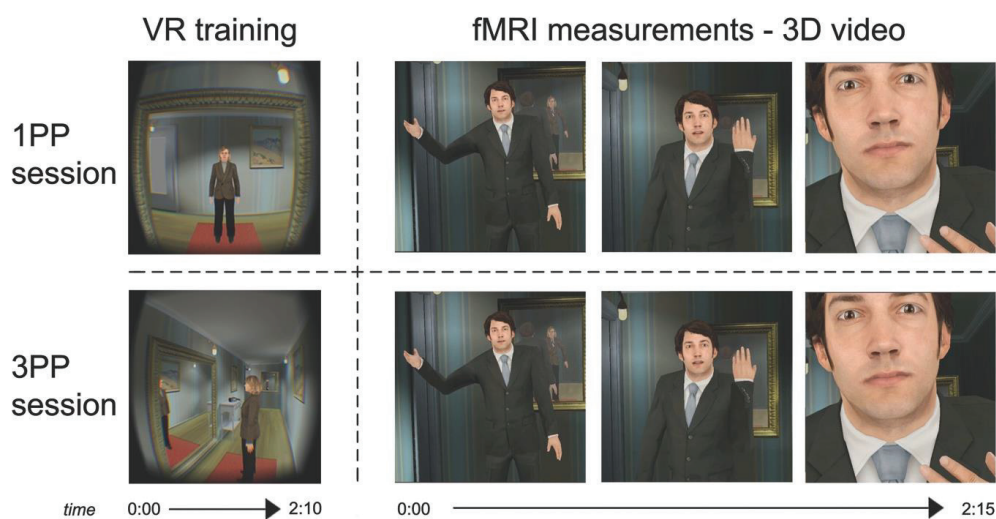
Experimental design. In two counterbalanced sessions, participants were immersed in a virtual reality scenario (VR exposure) where they either observed the scenario from a first person perspective and performed visuomotor exercises congruent with the female character's movements (1PP; top left), or observed the scenario from a third person perspective and performed visuomotor exercises congruent with the virtual camera's movements (3PP; bottom left). In both sessions, participants were subsequently moved to an MRI scanner, where they watched a continuous 3D video showing a domestic violence situation in which a male aggressor approached the viewer and entered their personal space (right).
